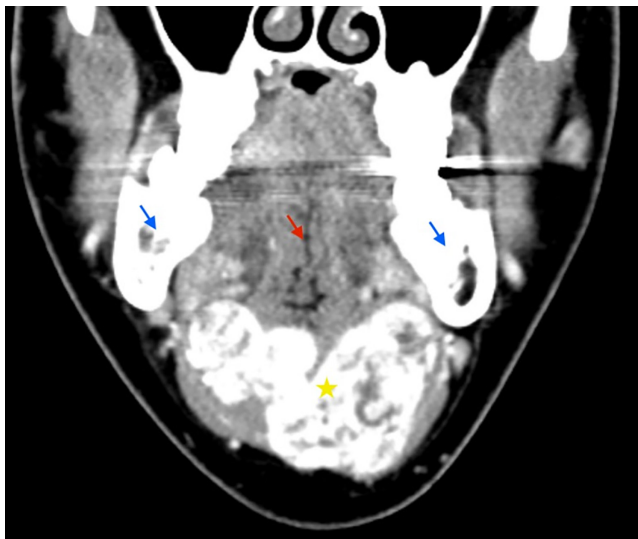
Neck CT scan with iv contrast, coronal view, with the large neck mass (star), just inferior and adjacent to tongue (red arrow) and mandible (blue arrow).
